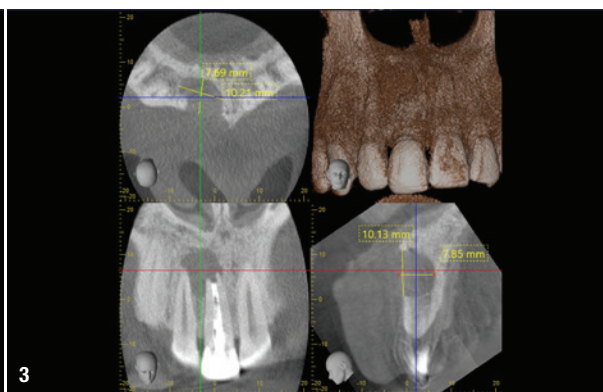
CBCT scan of failing tooth #11, showing inadequate root canal treatment and apical fenestration but an intact labial-crestal plate. — Fig. 3: Cystic cavity measuring approximately 10 × 8 mm.
